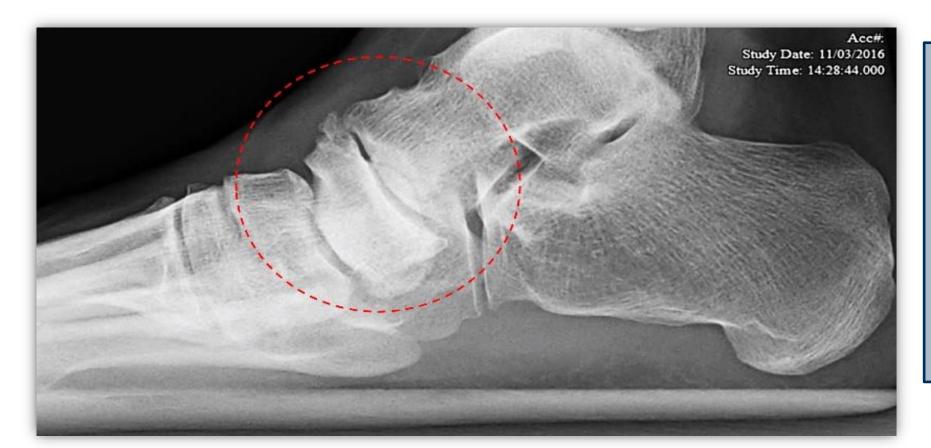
Plain film radiography with both primary and secondary signs of cubonavicular coalition present (dotted red circle)
